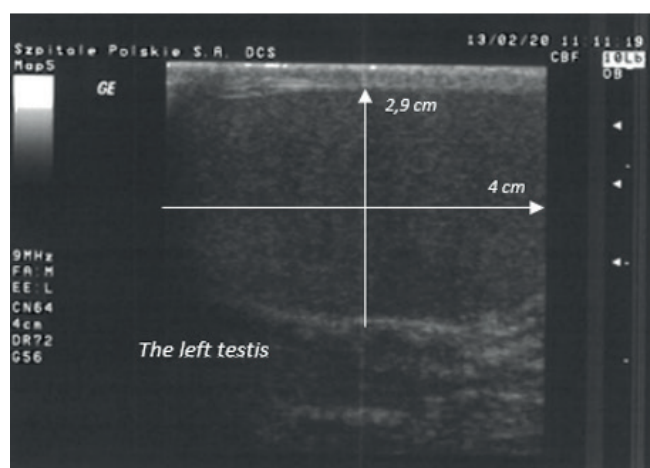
Ultrasound showed a normal left testis with normal echogenicity
